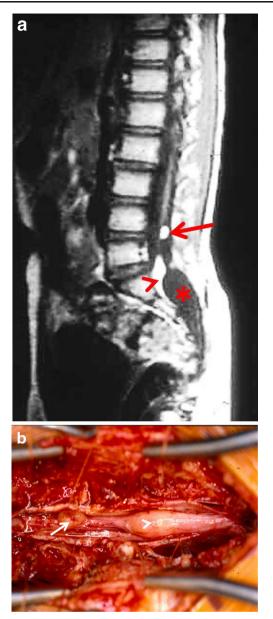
a, b Closed NTD—abnormal filum terminale. a T1-weighted sagittal MRI showing a low lying tethered spinal cord with a lipomatous mass at the conus medullaris (*arrow*) and at the filum terminale (*arrowhead*). In addition, an arachnoid cyst was present in the sacral region (*asterisk*). b Operative photograph of the findings noted in a. Lipomatous tissue of the conus medullaris (*arrow*) and the filum terminale (*arrowhead*). The arachnoid cyst has been fenestrated and is not visible. The filum was divided and the fatty tissue excised
